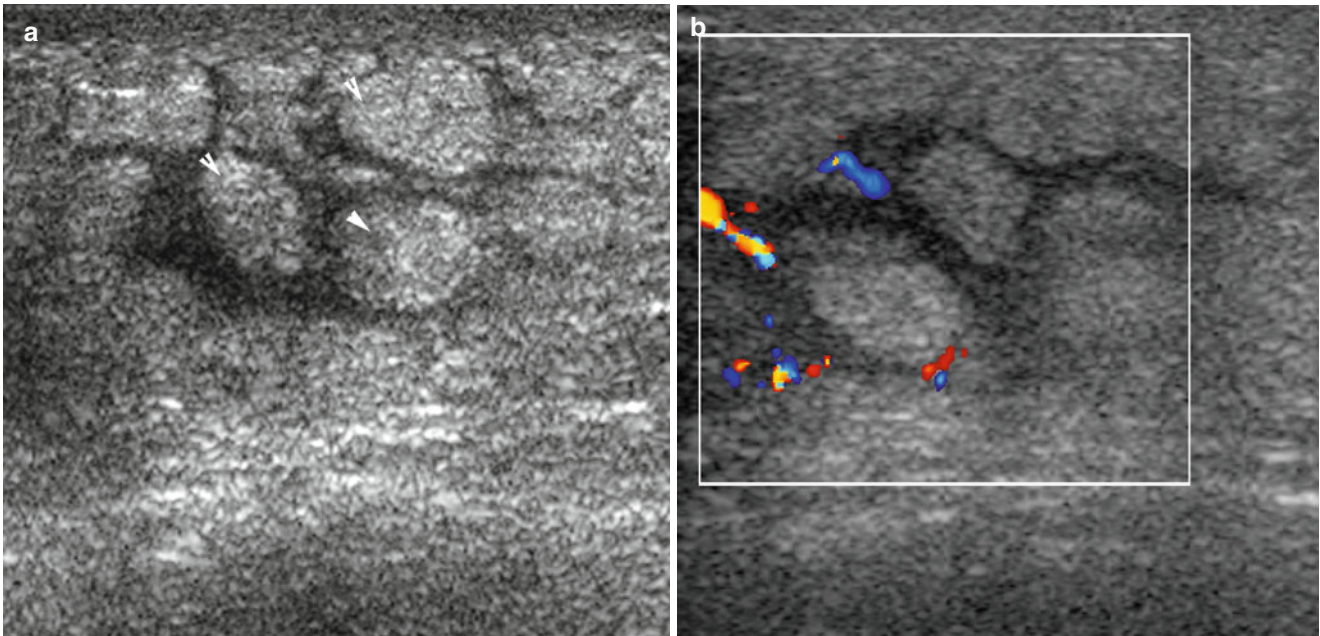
A 57-year-old female patient complaining of palpable mass on left upper quadrant abdominal wall. (a) Grey scale ultrasound image showing variable size homogeneous hyperechoic nodules (*arrowheads*)
